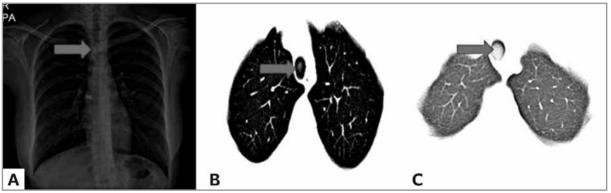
(A,B,C) A polypoid lesion (red arrows) protruding from posterior wall to lumen and narrowing the air column was seen on chest X-Ray and computed tomography.
